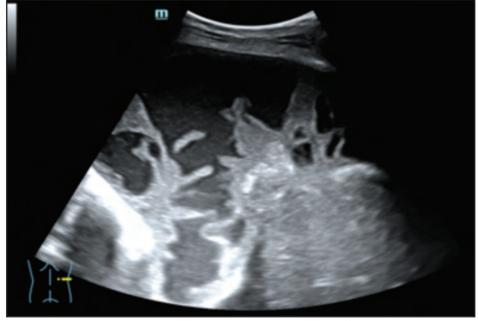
Thoracic ultrasound showing multiloculated right pleural effusion
